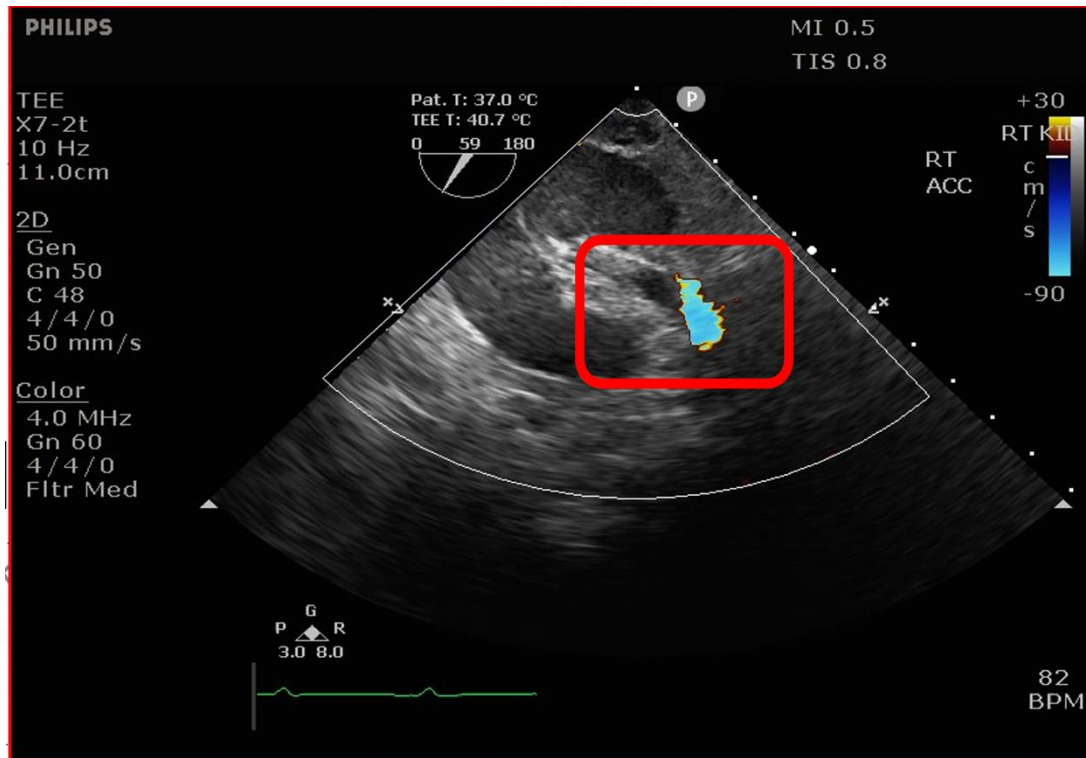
showing renal with renal artery using colour flow doppler
